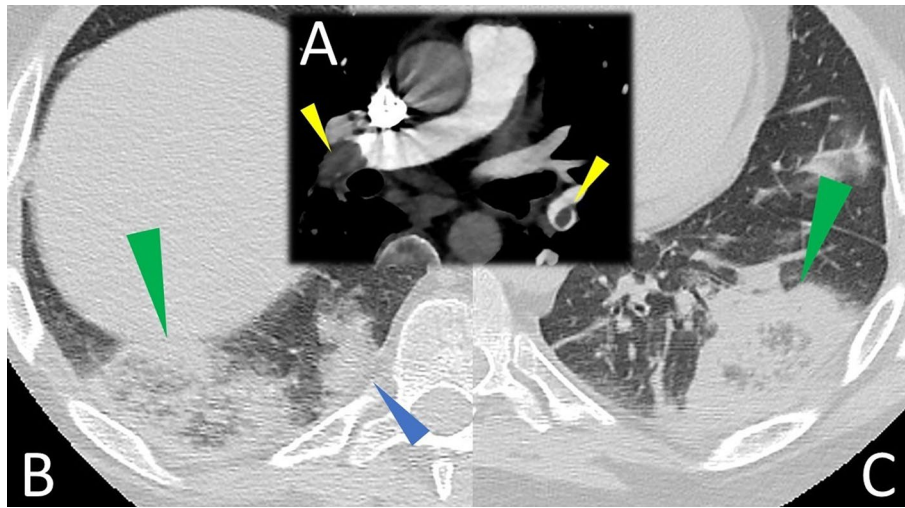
Axial (A) CT angiography of the pulmonary artery shows filling defects in the left and right pulmonary arteries (yellow arrowheads). An axial HRCT scan of the lung base reveals two reversed halo signs: (B) one in the lower right lobe, with an elliptical shape and subpleural location (green arrowhead), and another (C) in the lower left lobe, with a wedge-shaped and juxtapleural location (green arrowhead). A nodular reticulum-type pattern is appreciable within both areas of RHS (B and C). In the right lower lung lobe, a pulmonary infarction without aspects of RHS is also evident (blue arrowhead in B)
